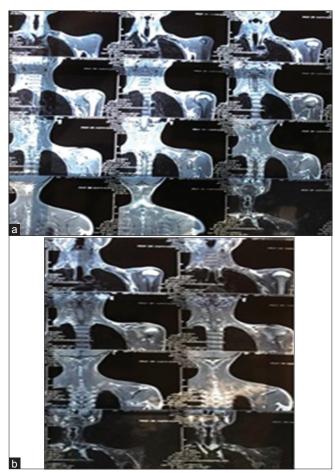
(a and b) Magnetic resonance imaging showing normal brachial plexus with normal shoulder girdle muscles
